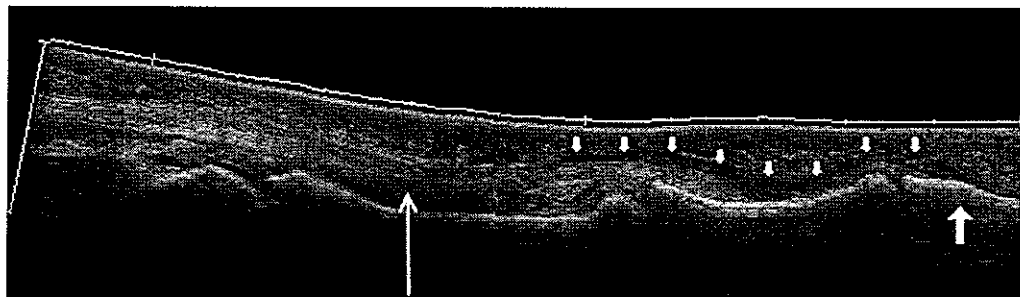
Panoramic ultrasound view of a closed FDP avulsion fracture. The small white arrows demonstrate the empty flexor sheath. The large arrow on the right indicates the level of the FDP insertion at the distal phalanx. The long arrow on the left demonstrates the level of the retracted FDP tendon, with associated haematoma around the proximal phalanx shaft.
